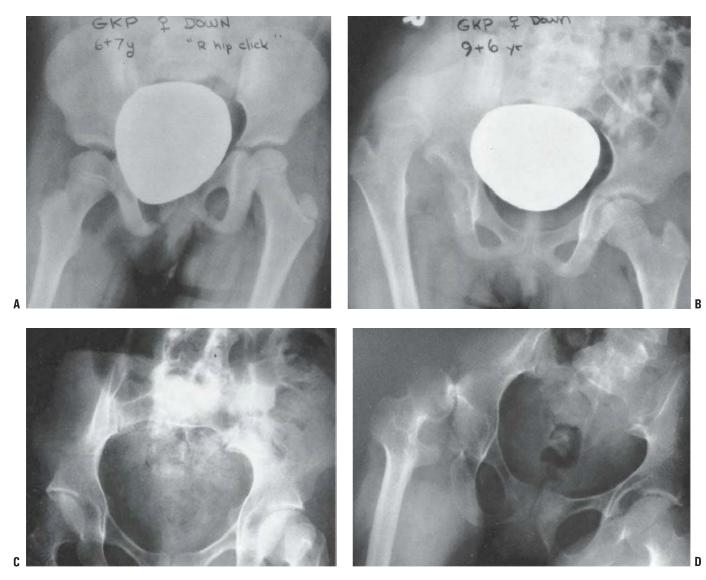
Down syndrome patient with late-onset developmental dysplasia of the hip and dislocation. A: Pelvic radiograph taken in standing position, at 6.5 years of age. B: At 9.5 years of age, the patient suddenly refused to walk because of hip dislocation. C: Pelvic radiograph of a 31-year-old man with Down syndrome. D: Three years later, dislocation of right hip occurred. (A and B, from Goldberg MJ. *The dysmorphic child: an orthopedic perspective.* New York, NY: Raven Press, 1987; C and D, from Pueschel SM. Should children with Down syndrome be screened for atlantoaxial instability? *Arch Pediatr Adolesc Med* 1998;152:123, with permission.)
